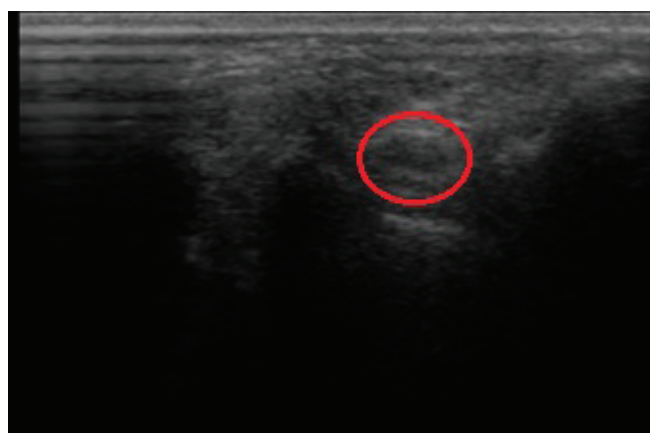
The ultrasonographic transverse view of the normal ulnar nerve at the elbow – in circle.
